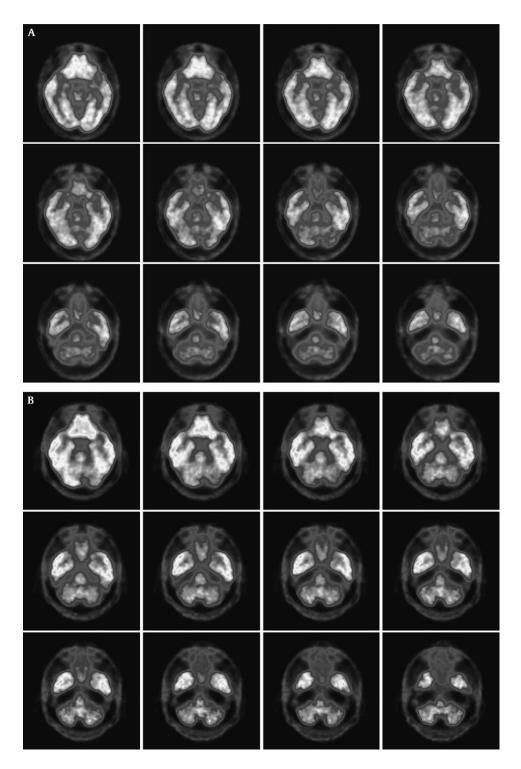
F-18FDG-PET studies performed with PPN-DBS stimulation turned off (A) and on (B). With both PPN-IPGs stimulators turned off, there was a pattern of diffusely decreased FDG uptake compared to normal brain, which was most prominent in the brainstem and both cerebellar hemispheres. With the PPN-IPGs turned on, there is a significant restoration of normal FDG uptake in the brainstem, cerebellar and probably the cerebral hemispheres.
